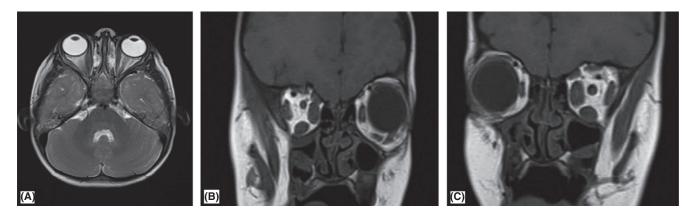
MRI scan of the same patient (A) Axial T2 weighted image showing enlarged EOMs, especially medial rectus; (B and C) Coronal T1 weighted images showing enlarged medial and inferior rectus.
